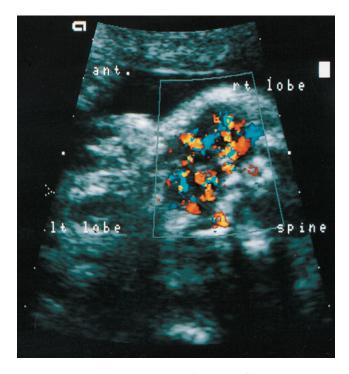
Prenatal sonographic image of a fetal neck demonstrating symmetric bilateral enlargement of the thyroid gland.
